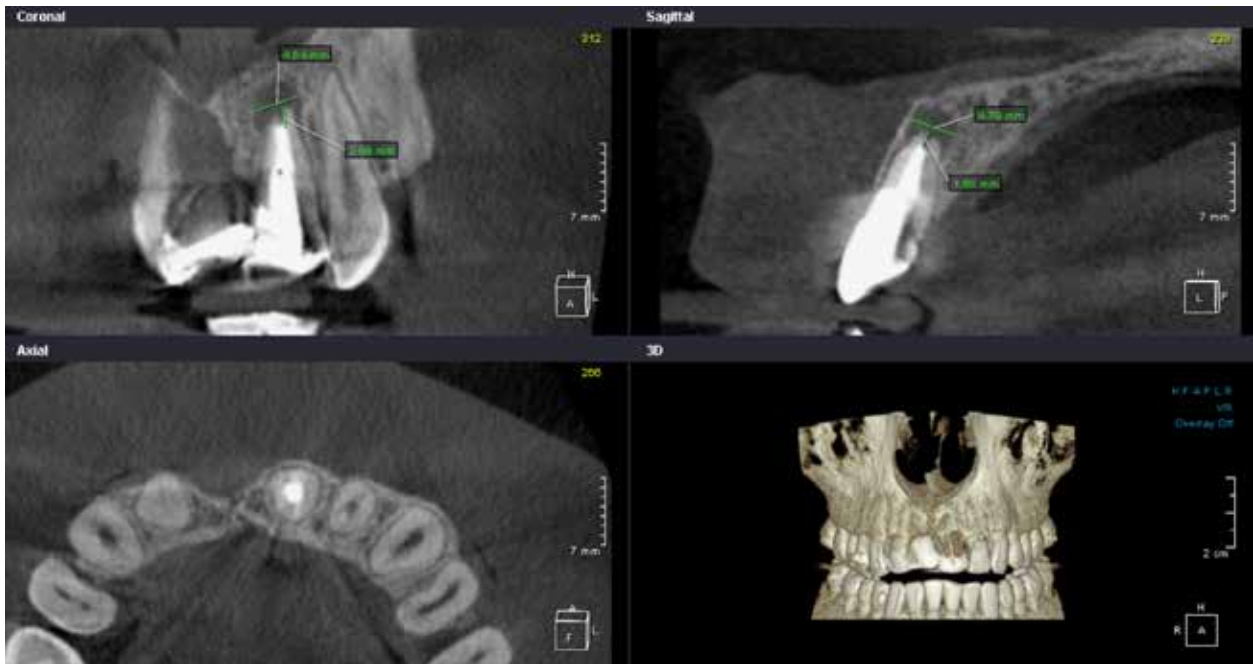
Assessment of endodontic treatment (L2H1CS1CF5) and apical periodontitis (S2RxD1) using the PESS index. L2 – root canal filling > 2 mm from radiographic apex, H1 – complete obturation (homogenous appearance of the root canal filling), CS1 – adequate coronal seal, CF5 – endodontically treated root with radiolucency, S2 – diameter of medium well-defined radiolucency 3-5 mm, Rx – no assessment, D1 – radiolucency around the root
